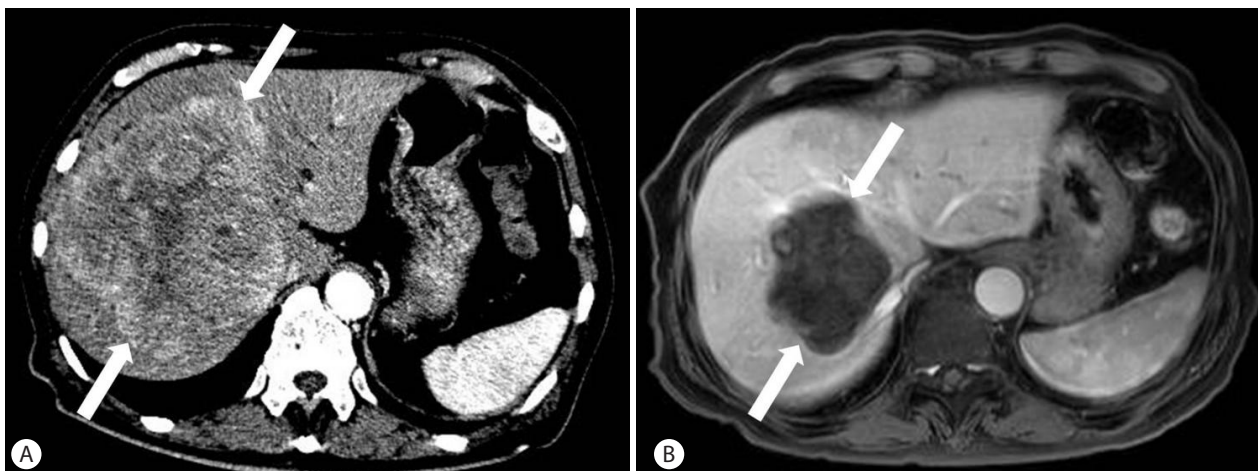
A 78-year-old man has 13 cm sized tumor in liver S4/8. Viral markers were negative, and Child-Pugh class was A5. Alpha fetoprotein was 769 ng/mL and PIVKA was 75,000 mAU/mL. (A) CT scan shows 13cm sized well-demarcated hypervascular tumor (arrows) in liver S4/8. (B) MR image 1 month after two sessions of TARE shows no enhancement of tumor (arrows). Note shrinkage of tumor to 7cm and hypertrophy of S2/3.
